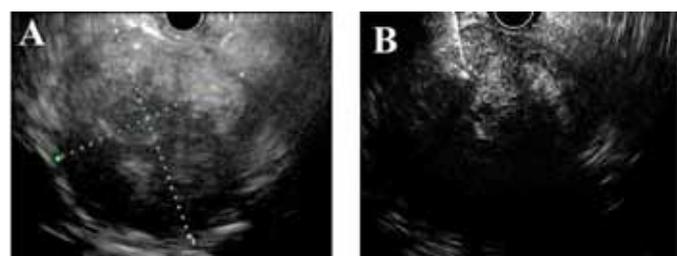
(A, B): Endoscopic ultrasound showing a well-demarcated hypoechoic mass with a central fluid and hyperechoic areas, which indicated intratumoral necrosis or hemorrhage.
